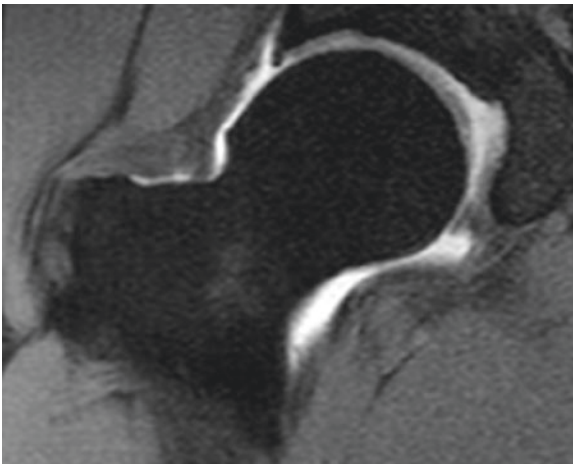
Left:* Acetabular cartilage delamination (“inverse Oreo sign”) on arthro-MRI. *Right:* arthroscopic view showing interruption of the chondrolabral junction
